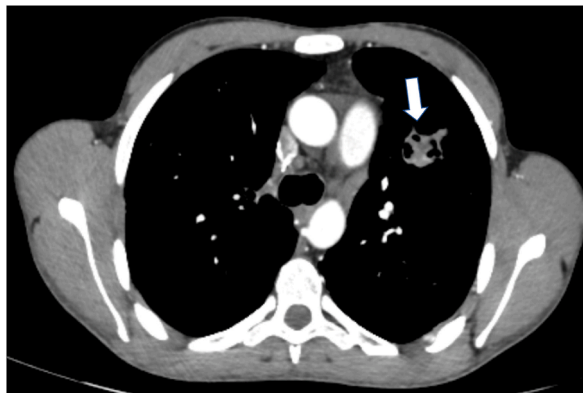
Axial post-contrast CT scan image: Heterogeneous pulmonary cystic image containing air in the left upper lobe (arrow).
